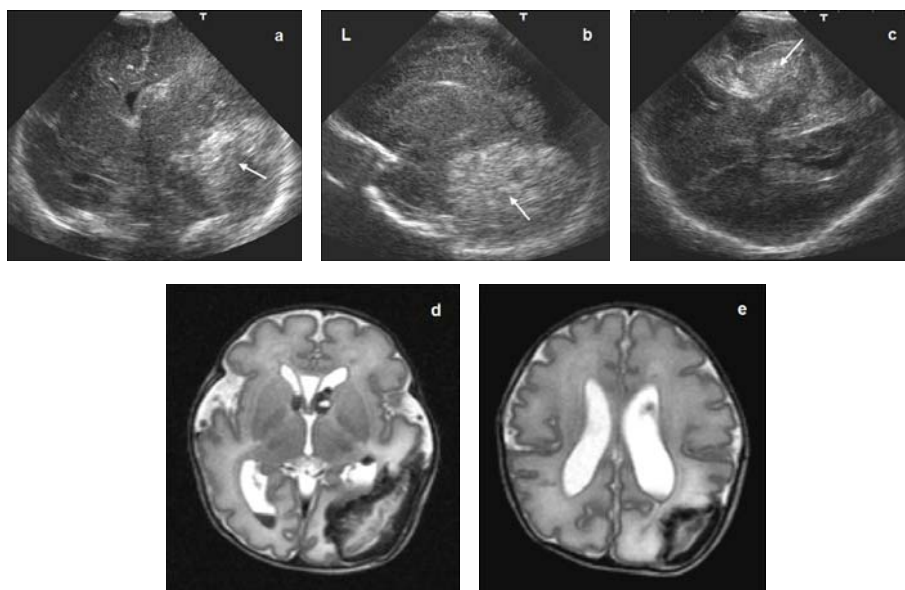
cUS in coronal (a), parasagittal (b) and mastoid view (c) from a 31-week infant with low platelets showing a large recent focal haematoma (long arrows) with a midline shift (a, short arrow). 20 cm³ of blood was removed by subdural drainage. MRI (d and e) following tap.
